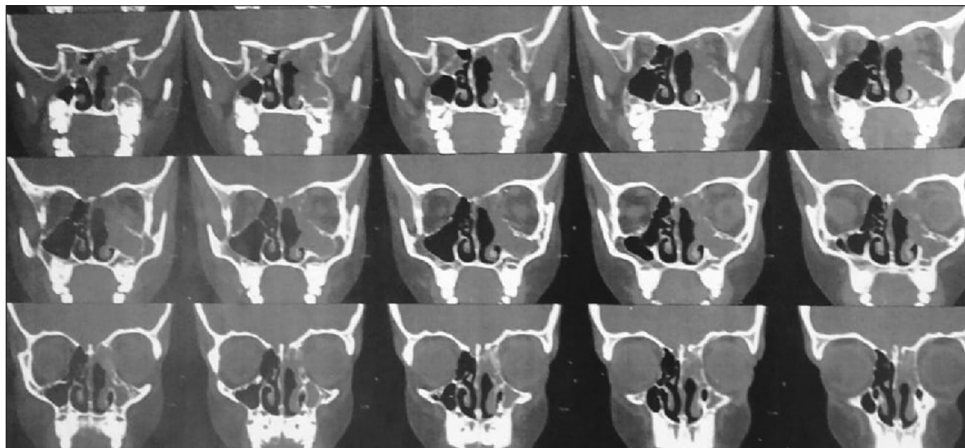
Postoperative computed tomography image shows a small residual tumor in the left compartment of sphenoid sinus and the left medial orbital wall and postoperative changes in the maxillary sinus.
